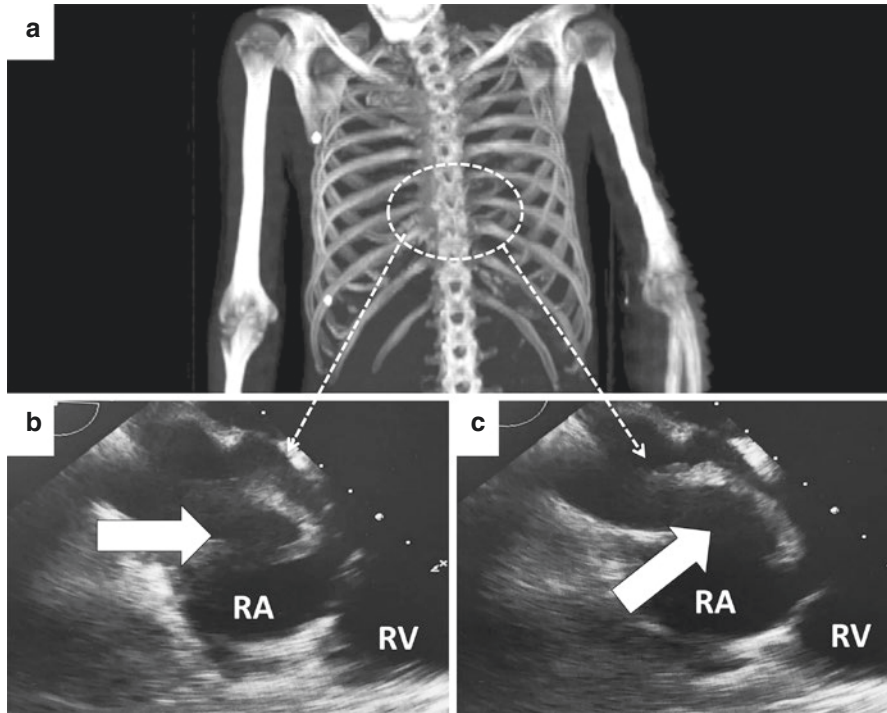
“Ghost” found at echocardiogram. After complete extraction of all hardware (Panel a) the transesophageal echocardiogram shows a tubular mass fluctuating inside the right atrium, called “ghost” (Panels b, c; white arrows). RA right atrium, RV right ventricle
